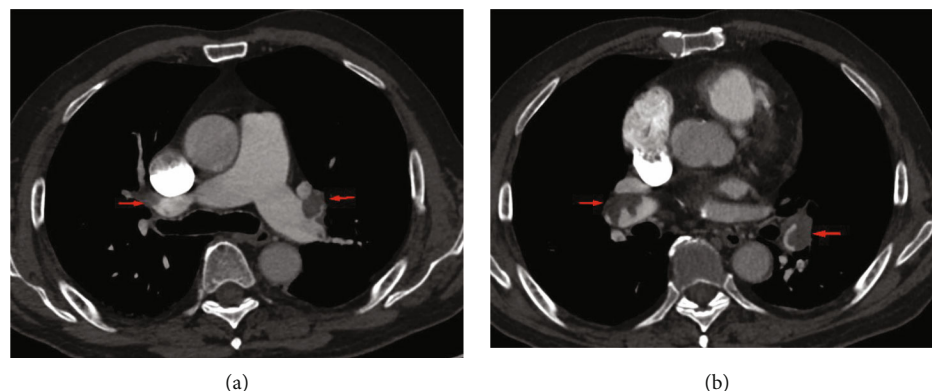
Computed tomography angiography (CTA) showed pulmonary embolism (yellow arrow) in the first patient (a, b).
